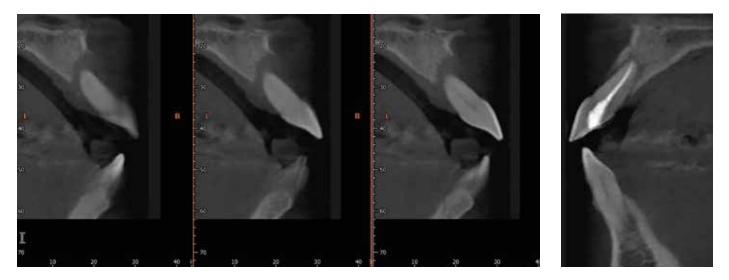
PTooth No. 8 presenting with perio-endo lesion preoperatively with blown out buccal plate (left). Figure 6: Tooth No. 8 presents with 9-month postoperative healing of peri-apical osseous defect on CBCT slides (right)
